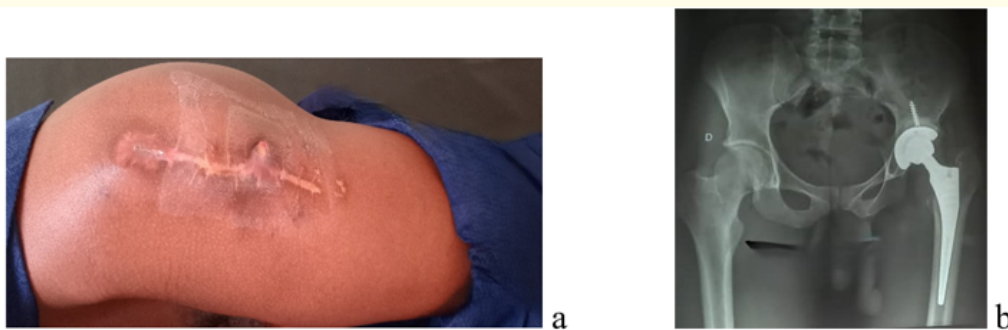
Superficial infection of the left total hip prosthesis: (a) clinical view; (b) radiographic image.
